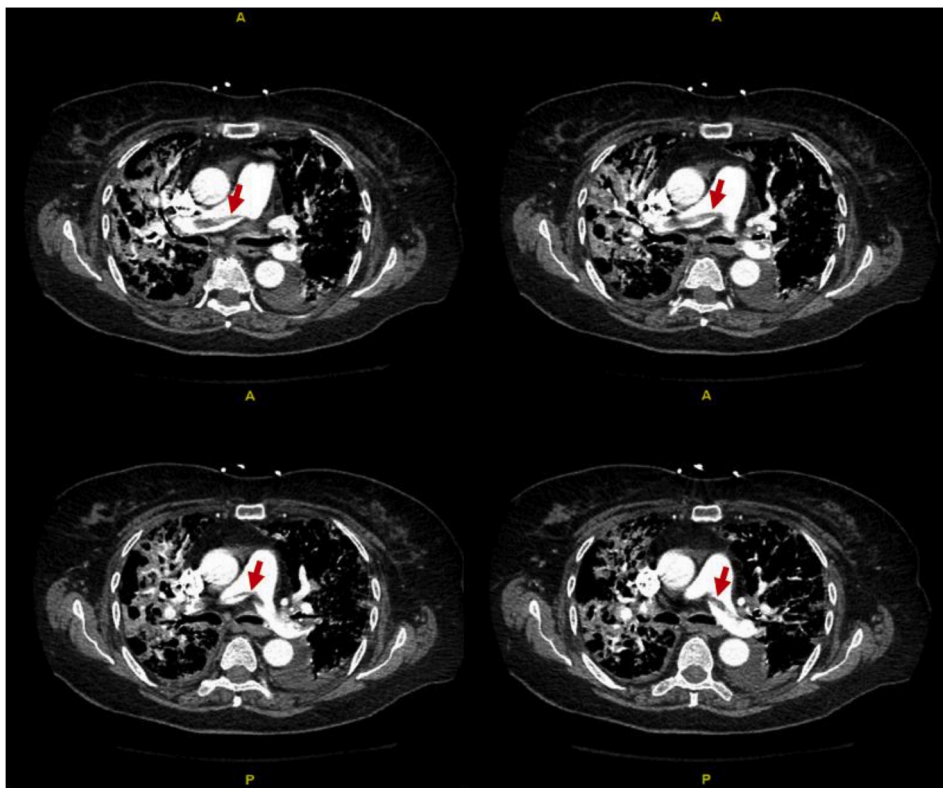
CTA chest reveals a saddle pulmonary embolism, as indicated by the arrows.
